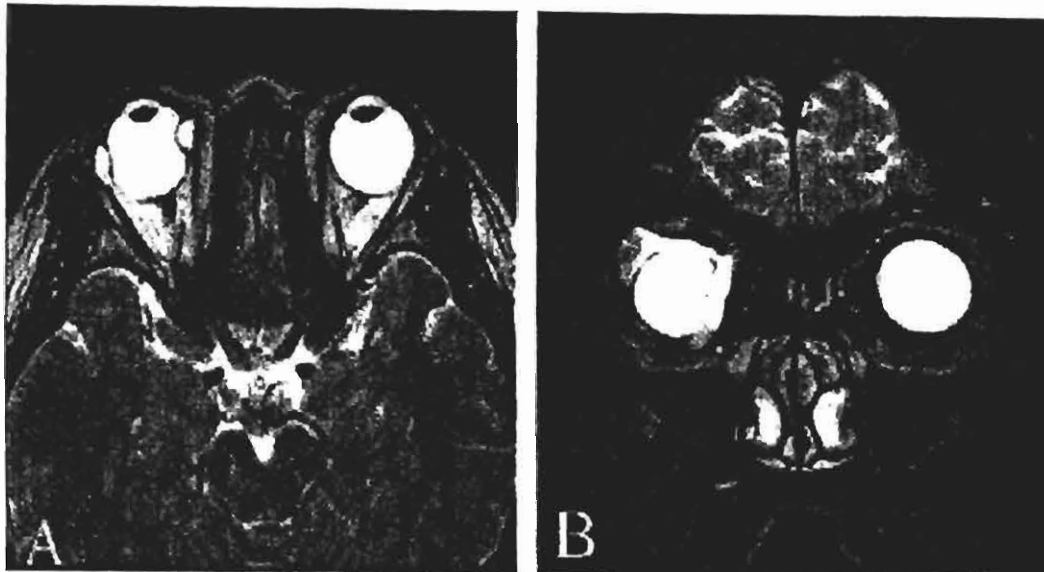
The magnetic resonance imaging documents the enlargement of the encircling Miragel explant. Sagittal view (A), Coronal view (B).
